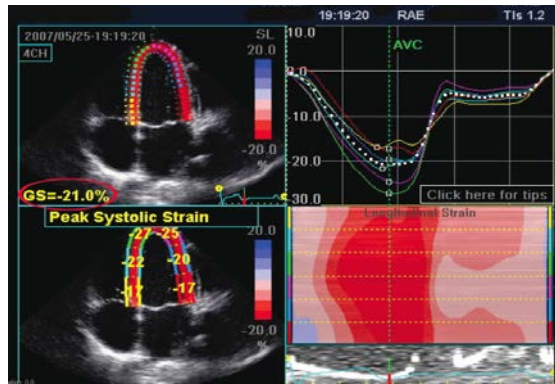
Two-dimensional longitudinal strain recording in the apical 4-chamber view of the heart of a subject with normal left ventricular systolic function. A segmental strain score is applied to each AHA myocardial segment. An overall strain score for that apical view is then automatically calculated (circled).
